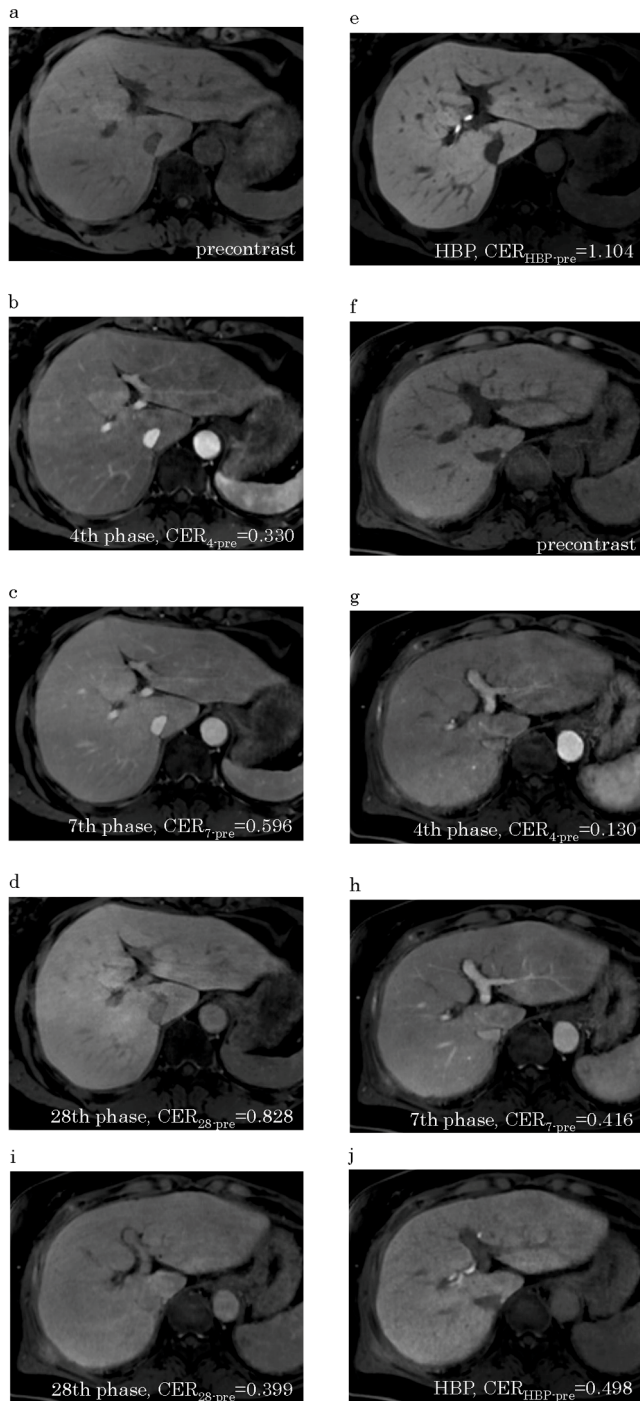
Free-breathing continuous multiphase dynamic EOB-MR images using CS and self-gating technique. (a)-(e) Precontrast (a), 4th (b), 7th (c), 28th (d) phases and HBP (e) images in a 65-year-old woman with sufficient HBP enhancement of the liver. (f)-(j) Precontrast (f), 4th (g), 7th (h), 28th (i) phases and HBP (j) images in an 86-year-old woman with insufficient HBP enhancement of the liver. The values of CER_{4-pre} , CER_{7-pre} , CER_{28-pre} and $CER_{HBP-pre}$ in these two patients were shown in the Figures.
